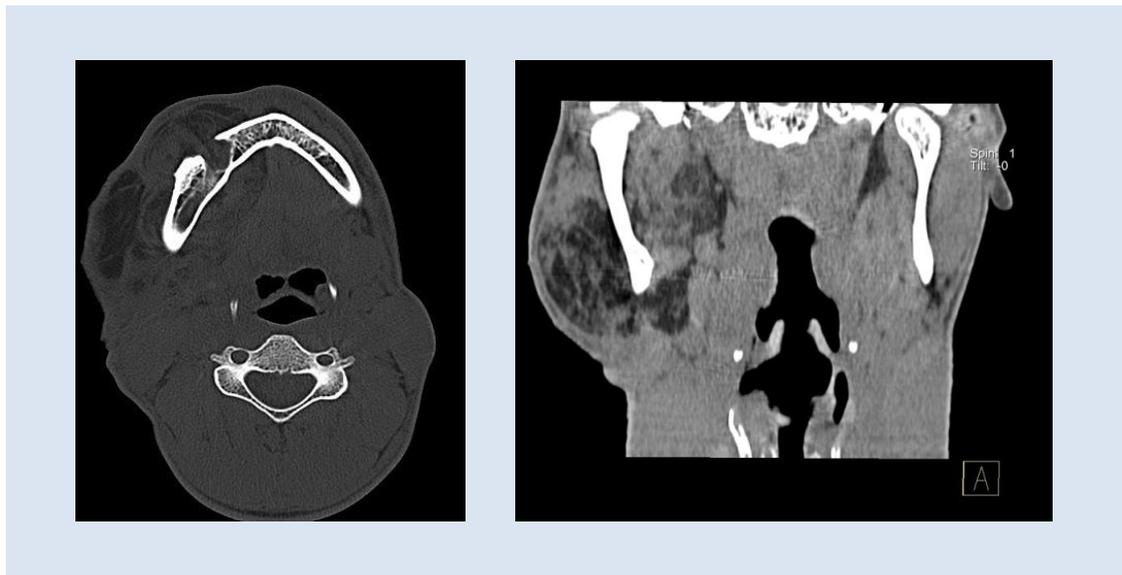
(A) Axial CT (bone algorithm) showing widened mandibular canal with fatty infiltration (thick arrow) and hyperplastic subcutaneous fat (B) coronal CT images demonstrates fatty infiltration of right masseter and pterygoid (arrow) muscles
